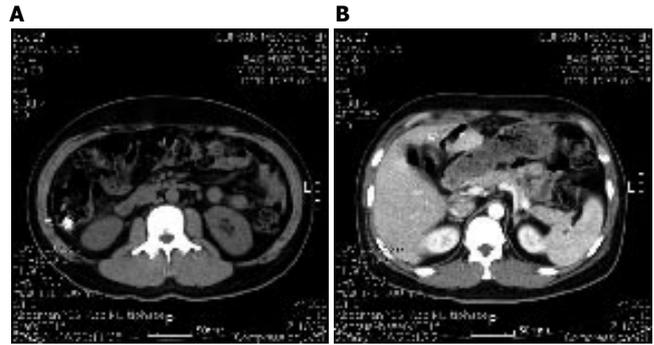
Abdominal computed tomography (CT) imaging. A: A metallic density in the ascending colon (arrow); B: A low density lesion penetrating the lateral section of the liver (arrow).
